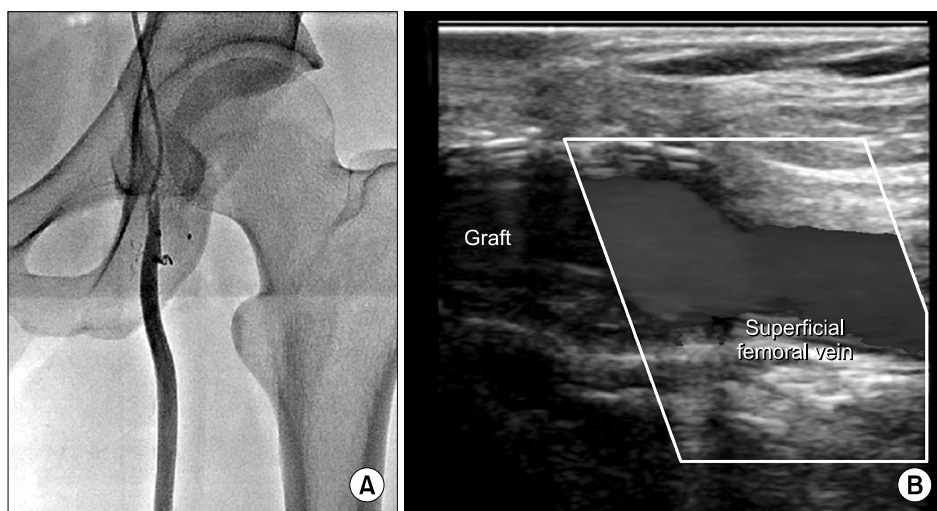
(A) The fistula was removed 6 months after surgery by coil embolization. (B) At 18 months after surgery, Doppler ultrasonography confirmed left femoral vein patency.
